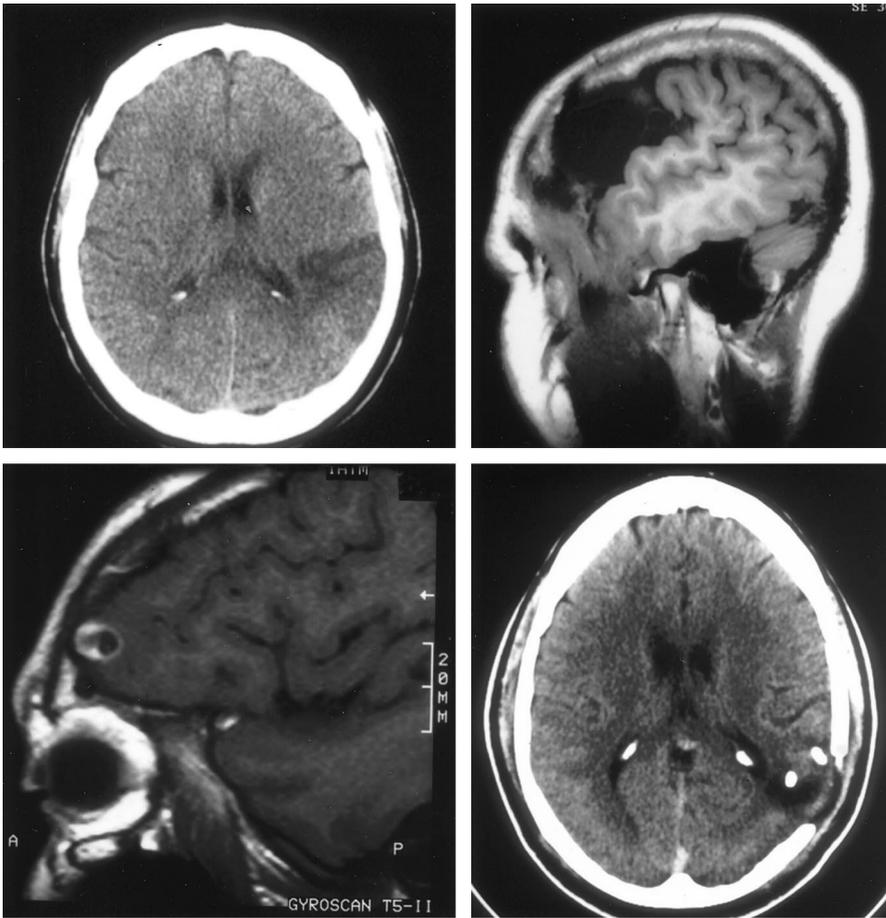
MRI and CT findings of four patients with “intractable seizures” and CNS lesions referred for epilepsy surgery who were found to have psychogenic seizures only. Patient 1: wedge-shaped stroke in the left MCA territory; Patient 2: right frontal porencephaly; Patient 3: neurocysticercosis, left frontal; Patient 4: remnants of bullet wound trauma to the right parietal region. See table for additional patient details.
